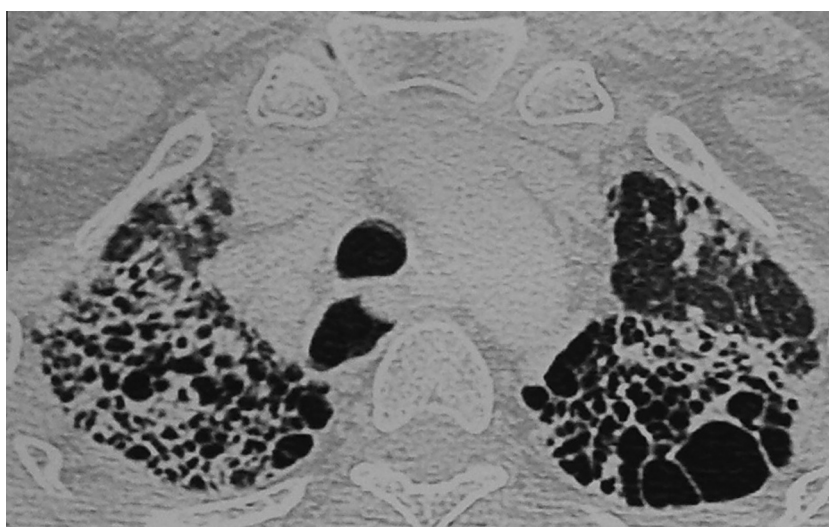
CT Chest showed bilateral ground glass opacities with extensive honeycombing in both lungs.
